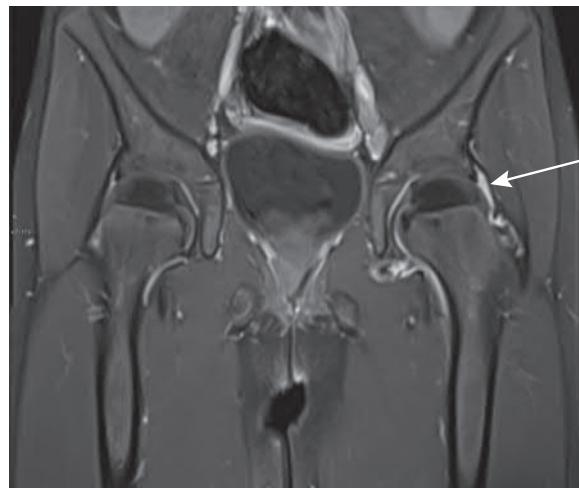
MRI scan (post contrast coronal T1 fat saturated) that demonstrates the enhancing synovium in the left hip (arrow) suggesting synovitis. Synovitis can be seen in both transient synovitis and early septic arthritis; they need to be differentiated by clinical examination and blood test results. (Courtesy of Dr Raj Sinha.)
